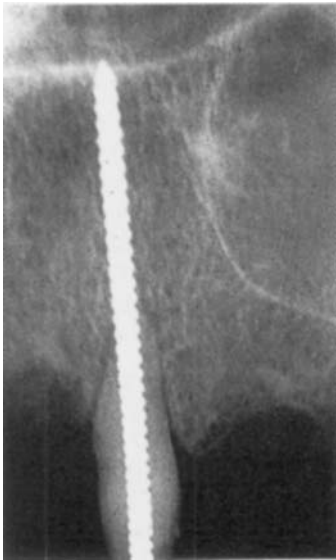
■ Postoperative periapical radiograph of seated stabilizer.
